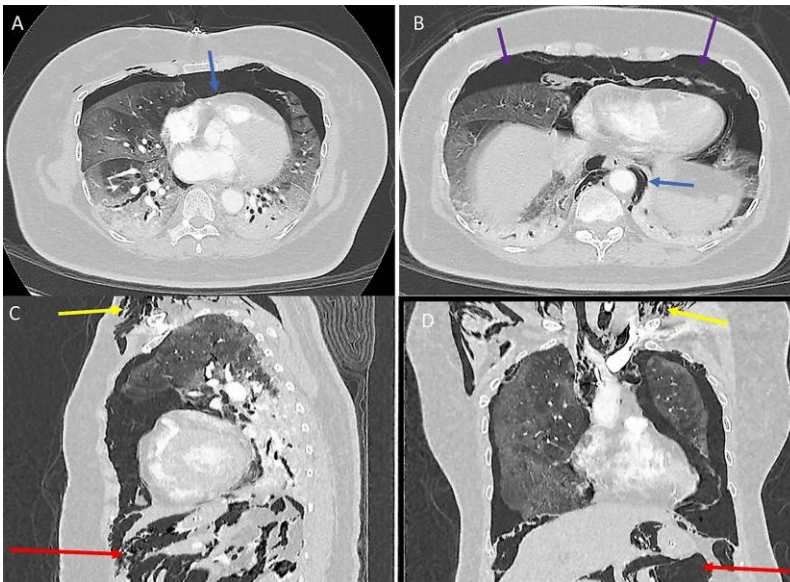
Axial images (A, B), sagittal reconstruction (C), and coronal reconstruction (D) of CT Thorax shows extensive subcutaneous emphysema at visualized lower neck (yellow arrow), extensive pneumomediastinum (blue arrow), bilateral pneumothorax with an extension of the air into the peritoneal cavity in keeping with massive pneumoperitoneum (red arrow) in the visualized upper abdomen. Diffuse ground-glass densities affecting both lungs with dense consolidative changes at the dependent area of lungs (purple arrow).
